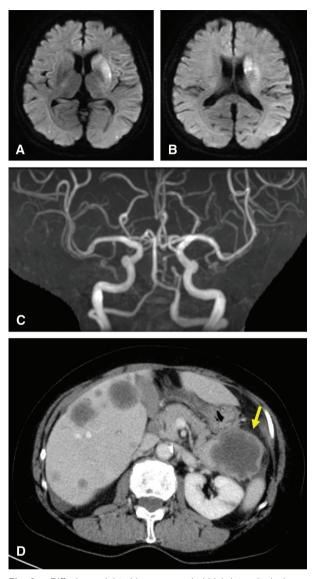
Diffusion-weighted image revealed high-intensity lesion on the left basal ganglia and corona radiata (A and B). MRA showed no abnormal findings (C). Contrast-enhanced CT revealed pancreatic cancer (arrow) with multiple metastases to liver, lung, and peritoneal dissemination (D).
